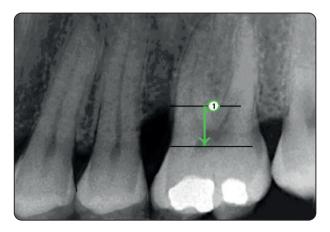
Baseline radiograph digitized image showing measuring infrabony defect depth.
